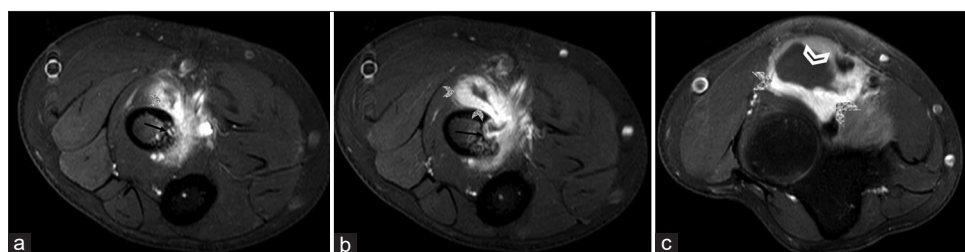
(a-c): Axial, post-contrast T1-weighted fat-suppressed MR images of the right elbow showing vivid peripheral enhancement (gray arrowhead) and central necrosis (open arrowhead). Bone involvement is also noted (black arrow)
